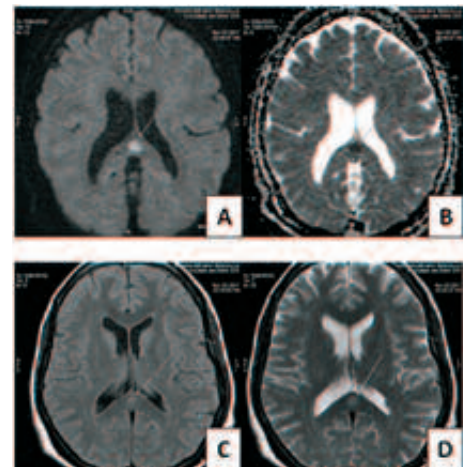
A) Diffusion weighted B) ADC (apparent diffusion coefficient map C) FLAIR and D) T2W Focal solitary area of diffusion restriction in splenium of corpus callosum with low ADC values. It exhibits T2W and FLAIR hyperintensity.
